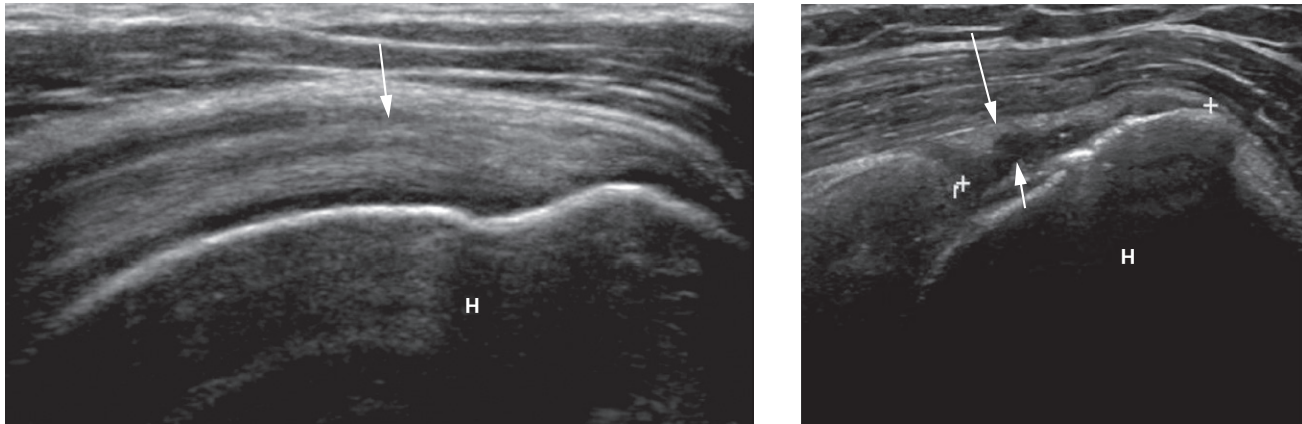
Ultrasound of the supraspinatus tendon. (a) Normal tendon (arrow) demonstrated at the level of insertion into the greater tuberosity of humerus (H). (b) The supraspinatus tendon is thin (long arrow) and there is a tear (short arrow) shown as low echogenicity, between the two caliper crosses. H, head of humerus.
